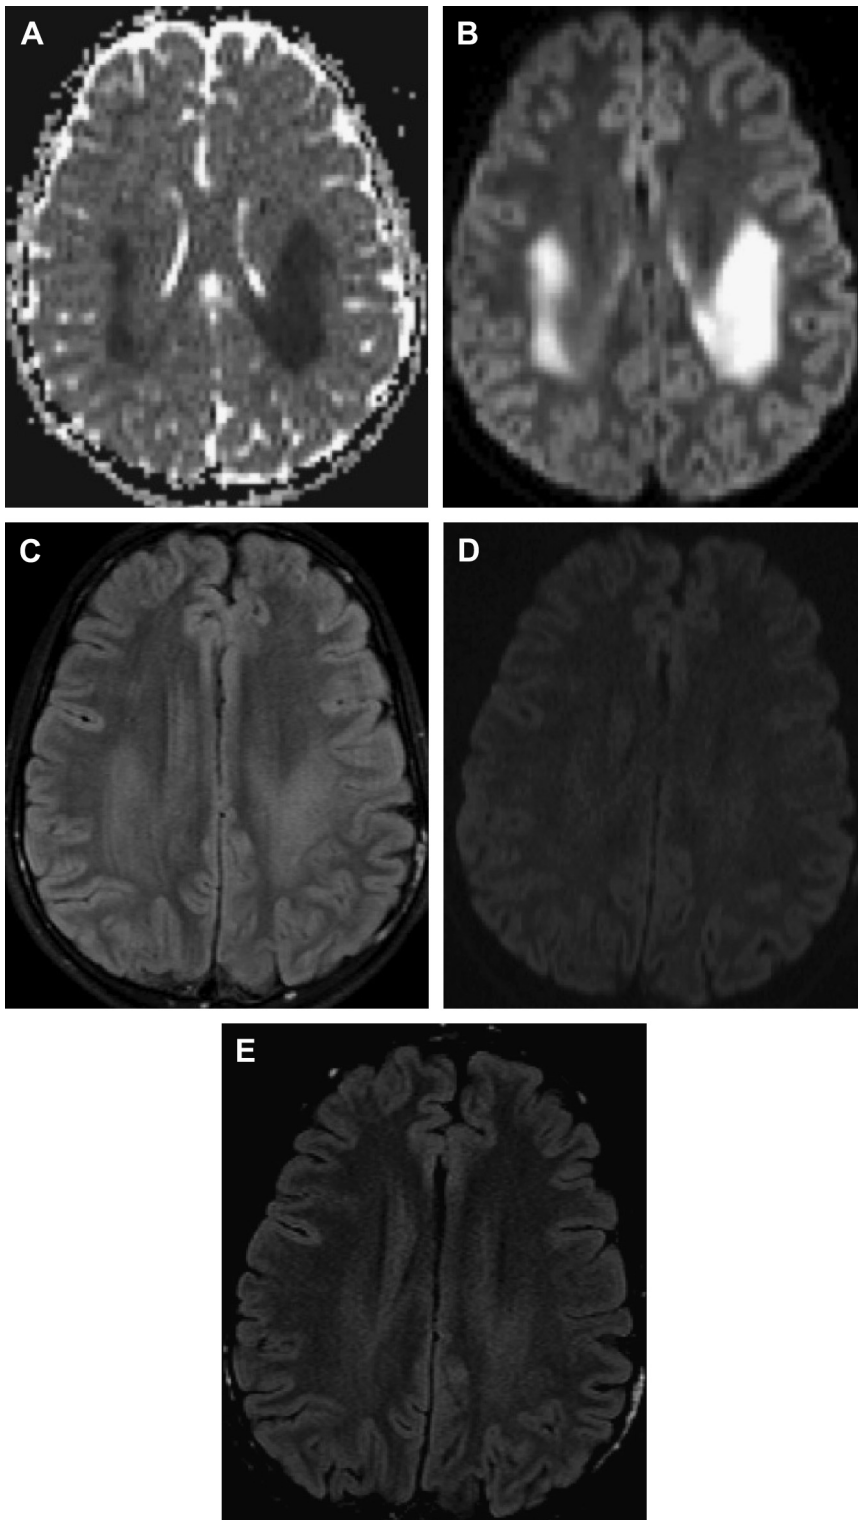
Fourteen-year-old boy with acute neurologic deficit, eventually diagnosed with X-linked Charcot-Marie-Tooth. Apparent diffusion coefficient and trace diffusion imaging maps (A, B) demonstrate profound restricted diffusion in the centrum semiovale with only a faint FLAIR signal abnormality (C). Neurologic symptoms spontaneously resolved and the MR imaging 1 year later demonstrates normal diffusion-weighted image trace (D) and near normal FLAIR (E) appearance.
